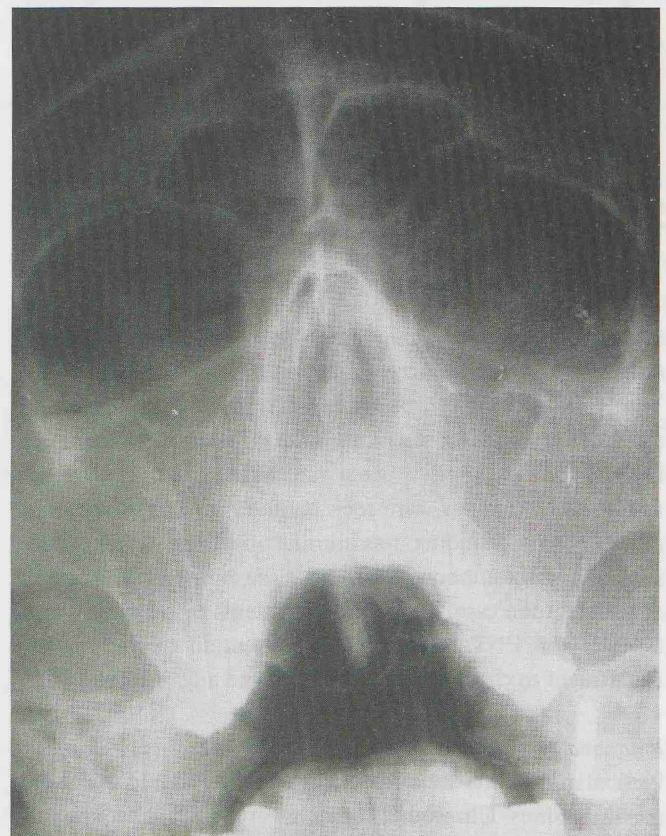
X-ray showing an intensive bilateral homogeneous shade of maxillary sinus.
